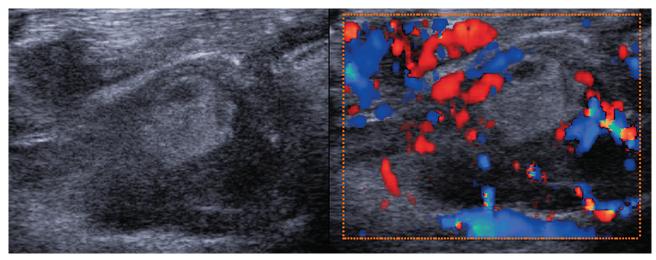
Left, Color Doppler ultrasonography showed an ill-defined lobulated hypoechoic mass. Right, The mass was highly vascular without calcification or cystic component.
